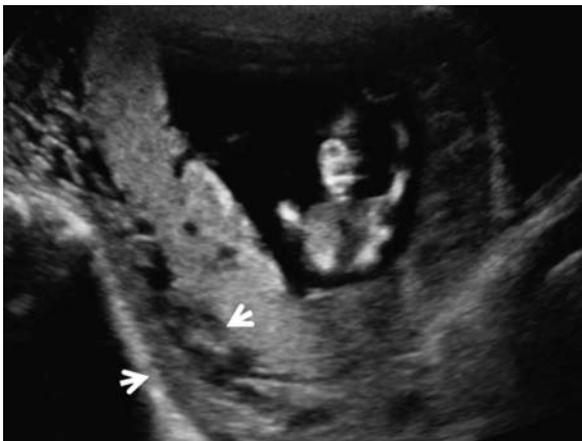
Normal placenta at 12-week gestation. Sagittal gray scale ultrasound image shows the hypoechoic "retroplacental complex" (short arrows).
